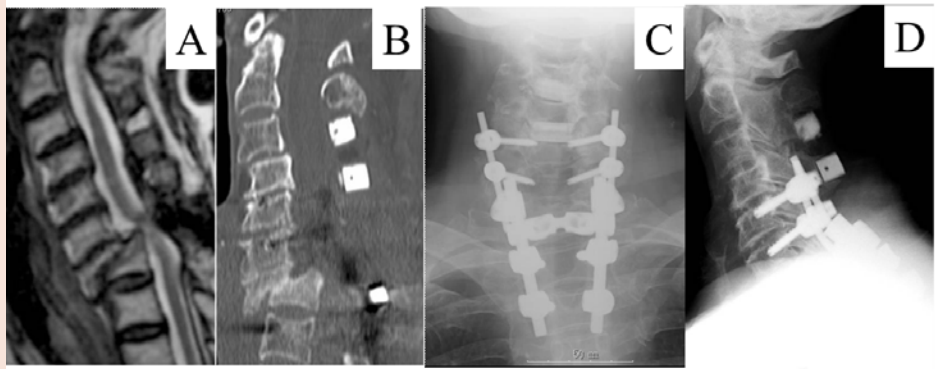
MRI T2-weighted sagittal image (A) and CT four years after laminectomy (the second surgery) revealed severe C7 anterolisthesis and cord compression at C7-T1. Plain radiography after decompression and fusion from C5 to T3 (C, D).
